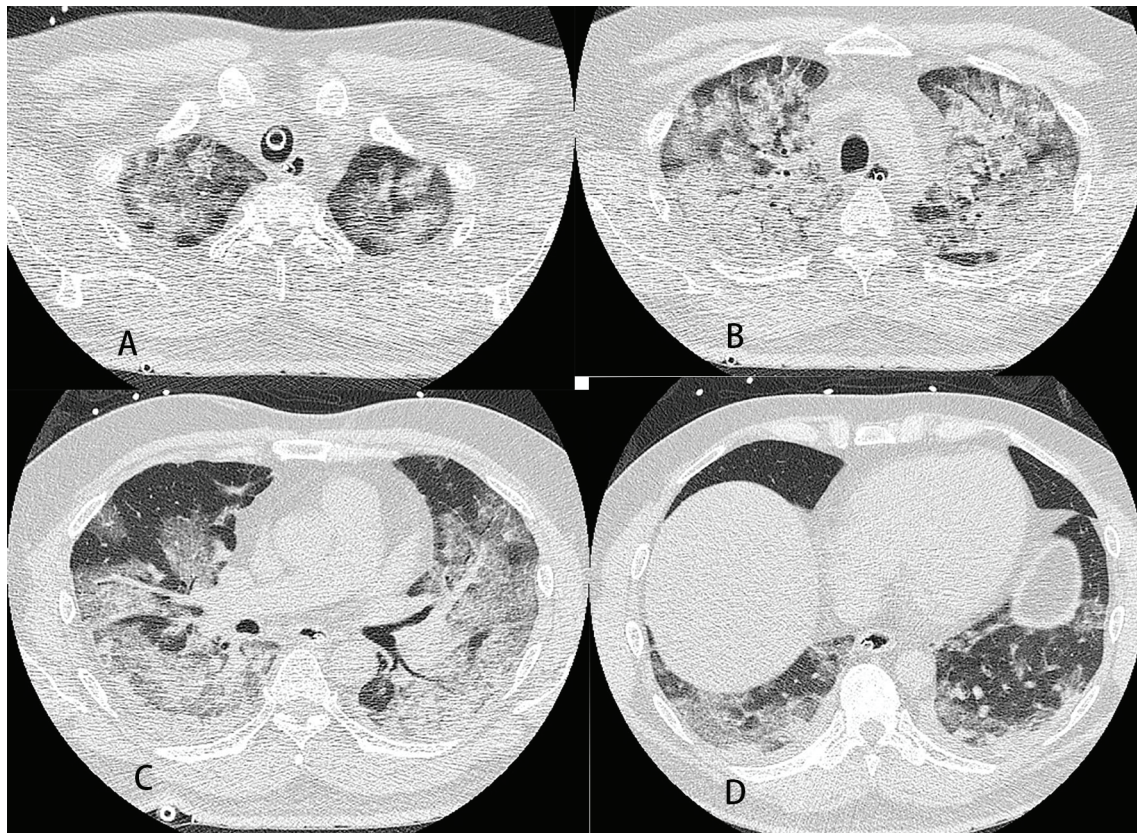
A-D: Chest CT showing bilateral opacity with an antero-posterior density gradient.
